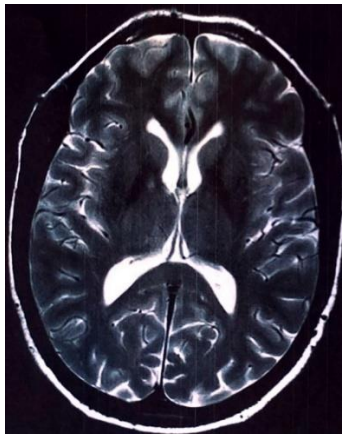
Axial T₂-weighted MR image of the human brain
